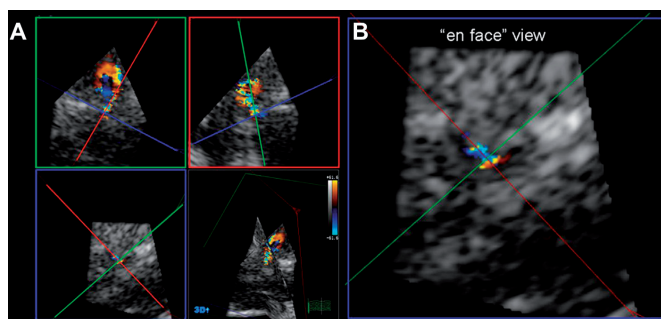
An example of a patient with eccentric aortic regurgitation. Multiplanar reformation of the 3D transthoracic Doppler echocardiography data sets (A) revealed an irregularly shaped effective regurgitant orifice area, as shown in the en face view (B).
